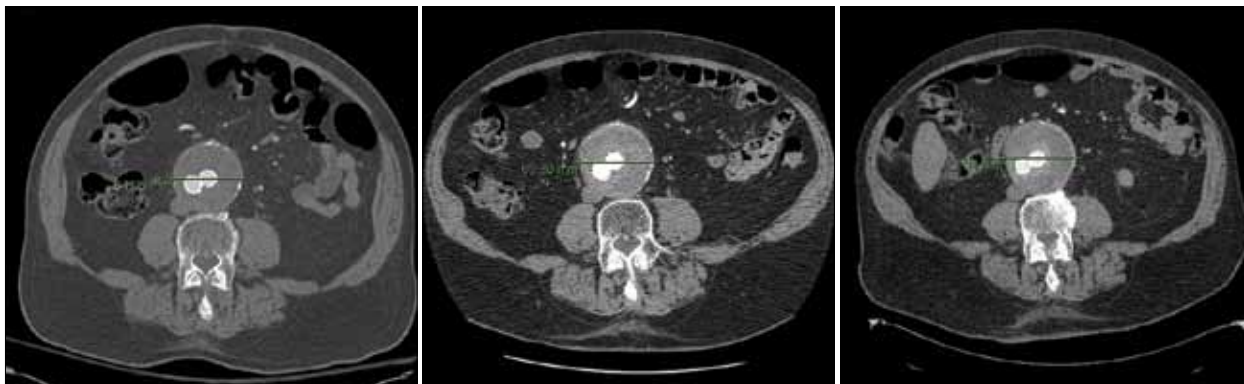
Surveillance CTA at 6-month intervals shows persistent aneurysm growth with no identifiable endoleak.
